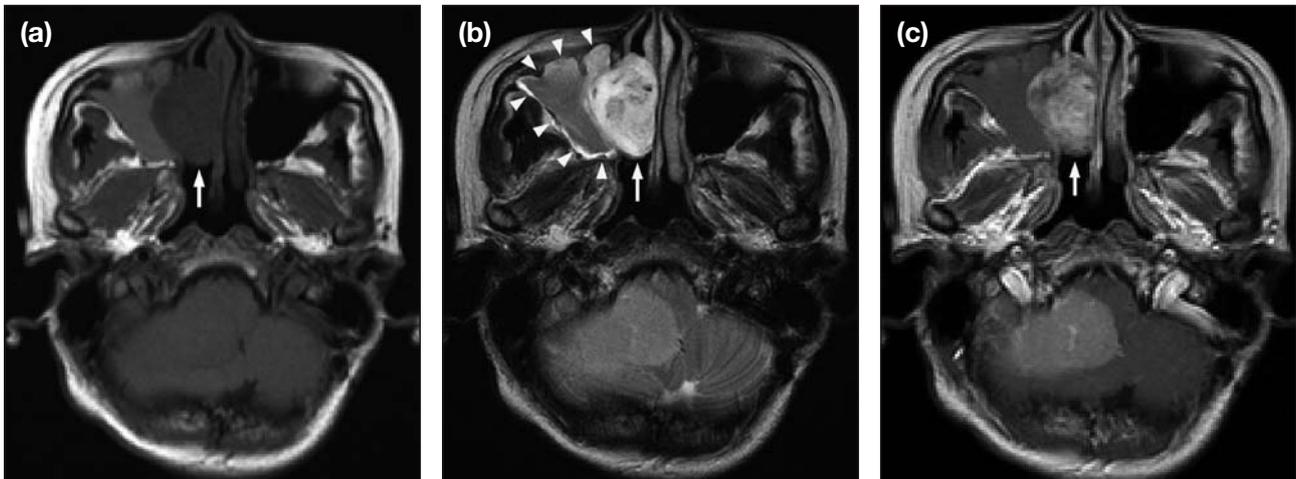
Magnetic resonance imaging features of the right nasal mass. (a) T1-weighted image showing a hypointense right nasal mass (arrow); (b) T2-weighted image showing a slightly heterogeneous hyperintense mass in the right nasal cavity (arrow) and an opacified right maxillary sinus (arrowheads); and (c) T1-weighted post-contrast image showing the corresponding right nasal mass with heterogeneous contrast enhancement (arrow).
